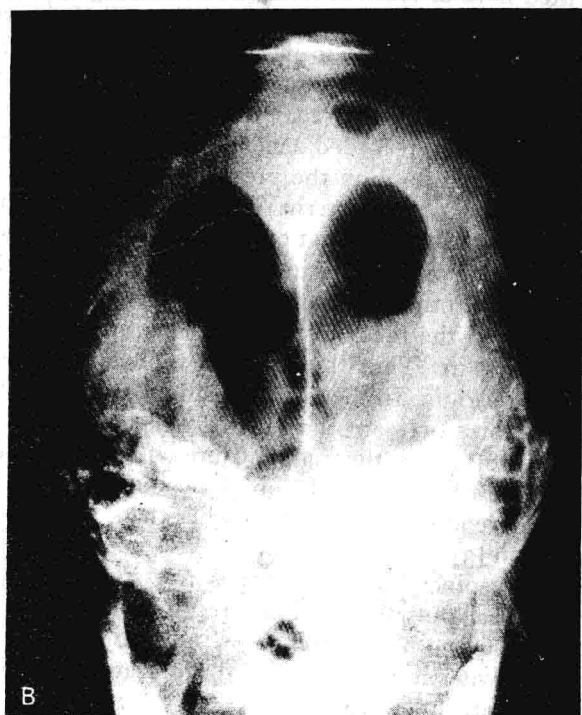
A B. Lateral and anteroposterior radiographs showing (hydrocephalic) ventricles filled with air.
